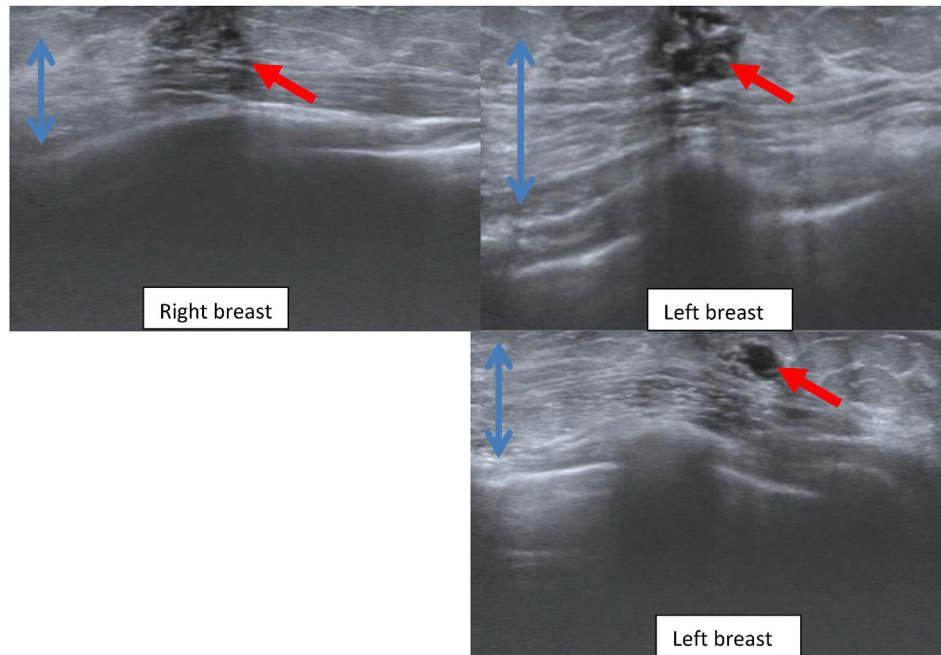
Ultrasound of the breast 3 years later: again showing the subareolar fibroglandular tissue bilaterally (two sided arrow) with mildly dilated ducts (one sided arrow) more prominent on the left.
